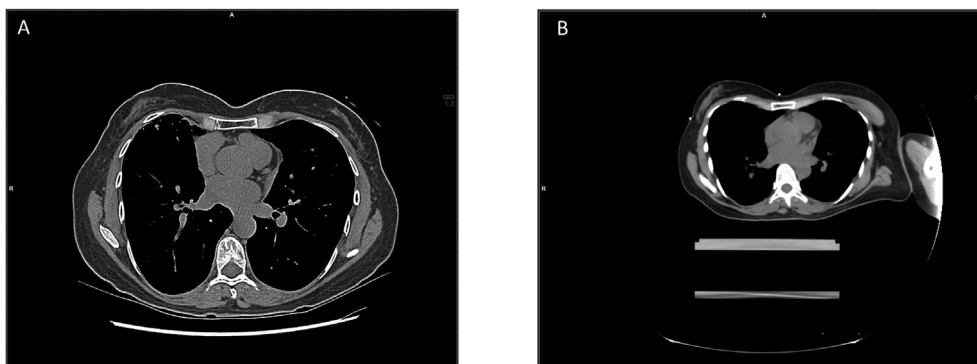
Image comparison between a CAC scan (A) and radiotherapy (RT) treatment plan CT (B) in a patient with breast cancer. This figure demonstrates how gated images (A) show cardiac substructures better in comparison with a larger field of view and lower spatial resolution RT treatment plan (B).
